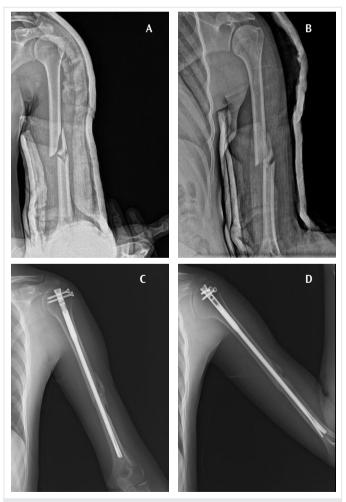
(A, B) Humerus diaphysis fracture preoperative bilateral X-ray image of a 32-year-old male, (C, D) bilateral X-ray image of the same case in postoperative  $12^{th}$  month
